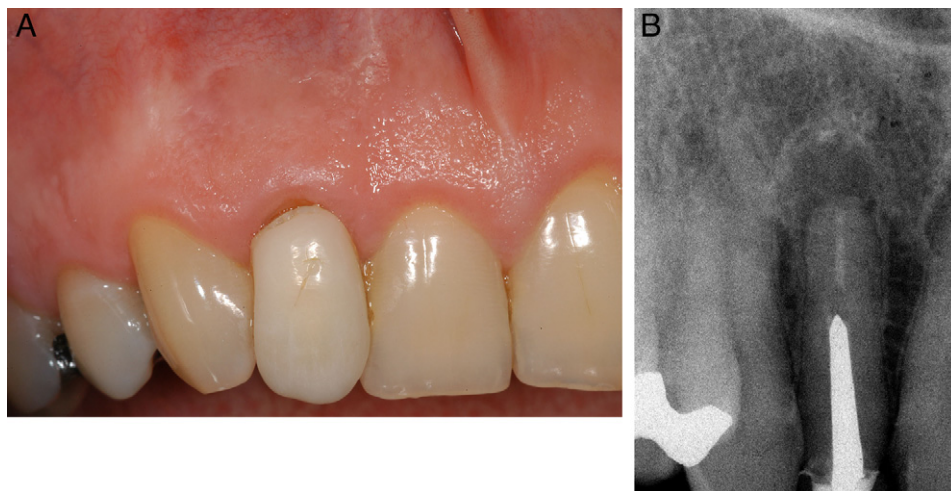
(A) The clinical situation of the right maxillary lateral incisor subjected to apical surgery in a 55-year-old male patient. (B) The periapical radiograph shows a distinct apical lesion.
